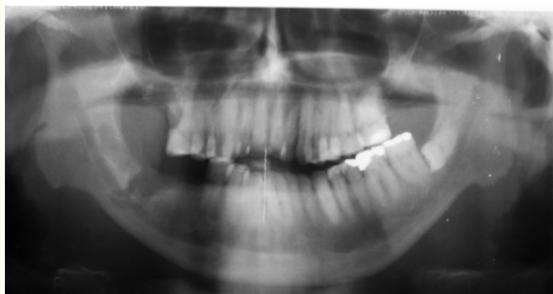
Panoramic radiograph showing diffuse radiolucent area, corresponding to the alveoli of elements 47 and 48, extracted 2 months ago, with no healing aspect compatible with the period.
